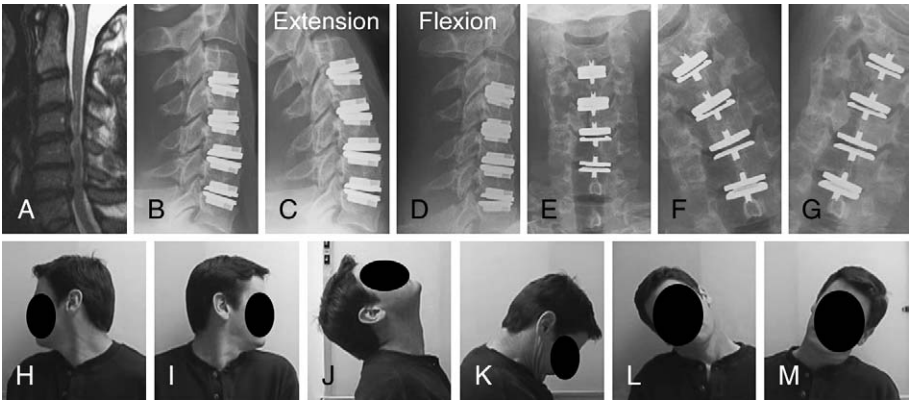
(A) Pre-operative sagittal T2-weighted MRI demonstrating significant disk herniations at C3-4, C4-5, C5-6, and C6-7. Post-operative cervical spine radiographs following 4-level Prodisc-C arthroplasty in (B, E) neutral position, (C) extension, (D) flexion, (F) right lateral bending, and (G) left lateral bending. Video snapshots of the same patient at 6 month follow up showing excellent range of motion in (H) right rotation, (I) left rotation, (J) extension, (K) flexion, (L) right lateral bending, and (M) left lateral bending.
